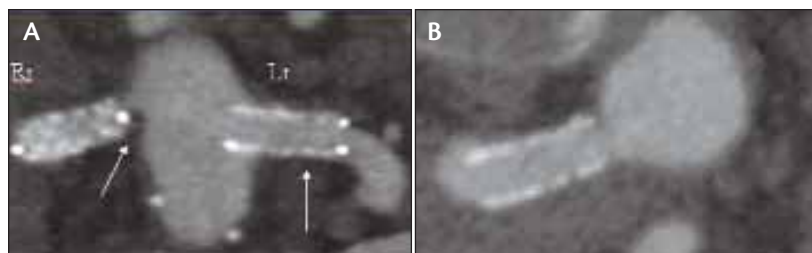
Follow-up CTA of renal stents revealing the right stent to be off of the ostium by approximately 1 mm, possibly setting up hyperplasia (A). The left is widely patent. The axial image confirms the placement of the right renal stent to be just off the ostium with the aorta (B). Although this patient does not have it, placement just past the ostium is crucial in patients with abdominal aortic aneurysms, for the mural thrombus of the aortic wall can shift and cover the stent.
